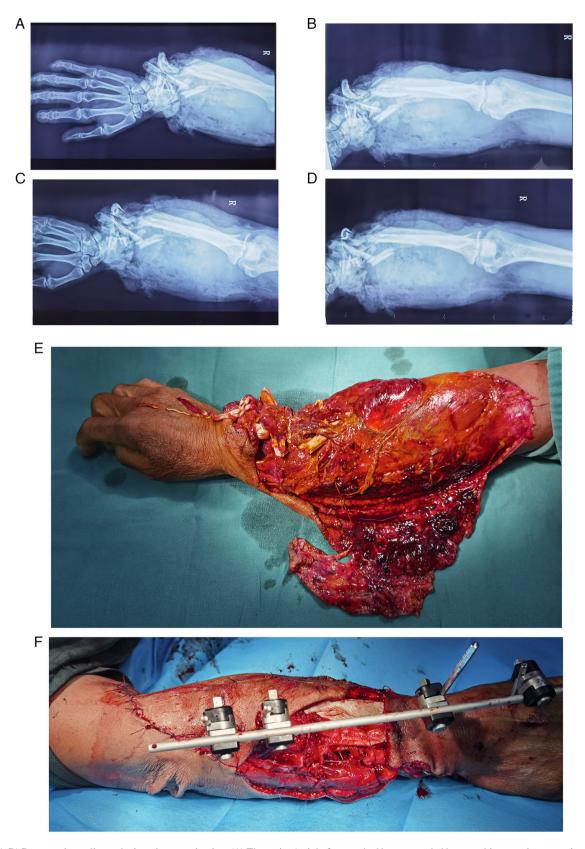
(A-D) Preoperative radiography imaging examination. (A) The patient's right forearm had been wounded by a machine, causing comminuted fracture of the distal radius and the right ulna, and broken ends of the ulna and radius had caused tissue puncture. (B) The distal wrist joint was intact with no obvious fracture signs. Forearm soft-tissue swelling was observed with distal radius bone residue of ~2.5 cm. (C) Soft-tissue swelling was obvious in the far distal joint but there was no significant fracture in the elbow joint. (D) The distal ulna and radius fractures were crushed and certain fragments protruded out of the soft tissue. (E) Image of the wounded arm after cleaning, hemostatic strap bleeding and disinfection; the patient had forearm soft-tissue swelling, skin degloving, degloved skin contusion and distal dorsal forearm defect, distal dorsal muscle rupture, exposed fracture fragments, residual tendon and an intact distal wrist joint. (F) Intraoperative image. The forearm was fixed with an external fixator for a short duration during the *in situ* replantation of the degloved skin. Distal dorsal soft-tissue defect wounds were observed. Polymethyl methacrylate was used to fill the distal radius defect. A Kirschner wire is visible on the ulnar side of the forearm, which was used to fix the distal radioulnar joint. The free fragments of the ulna fracture were removed and discarded, and obvious ulna bone defects are visible.
